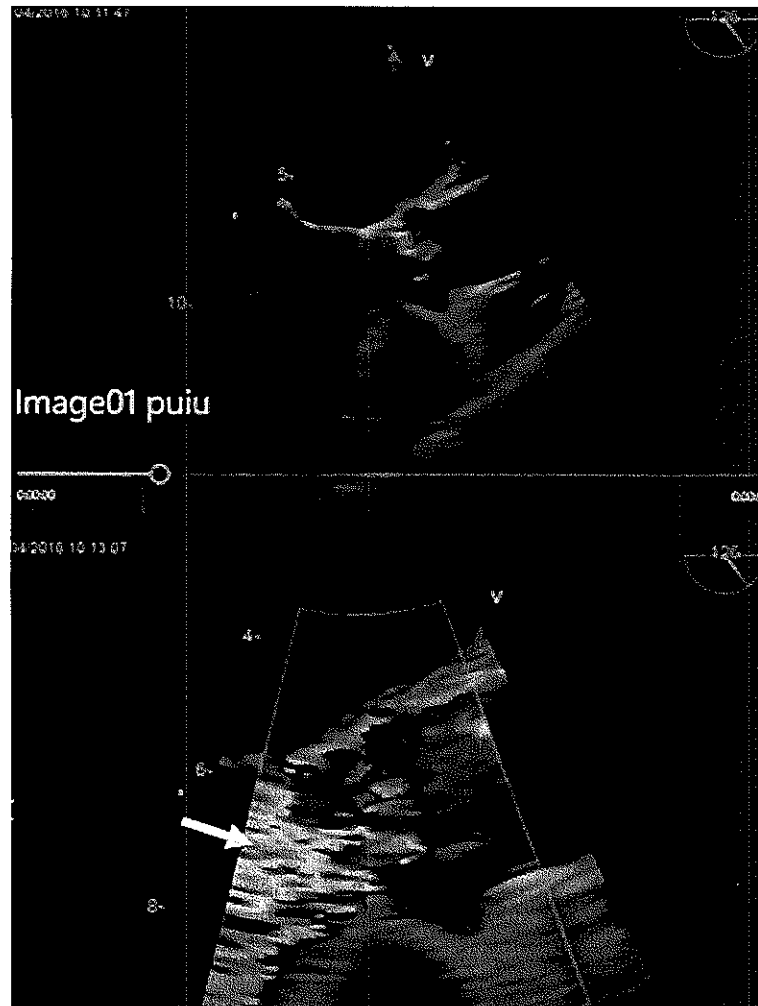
Echocardiographic image showing the aortic valve vegetation and aortic regurgitation.
